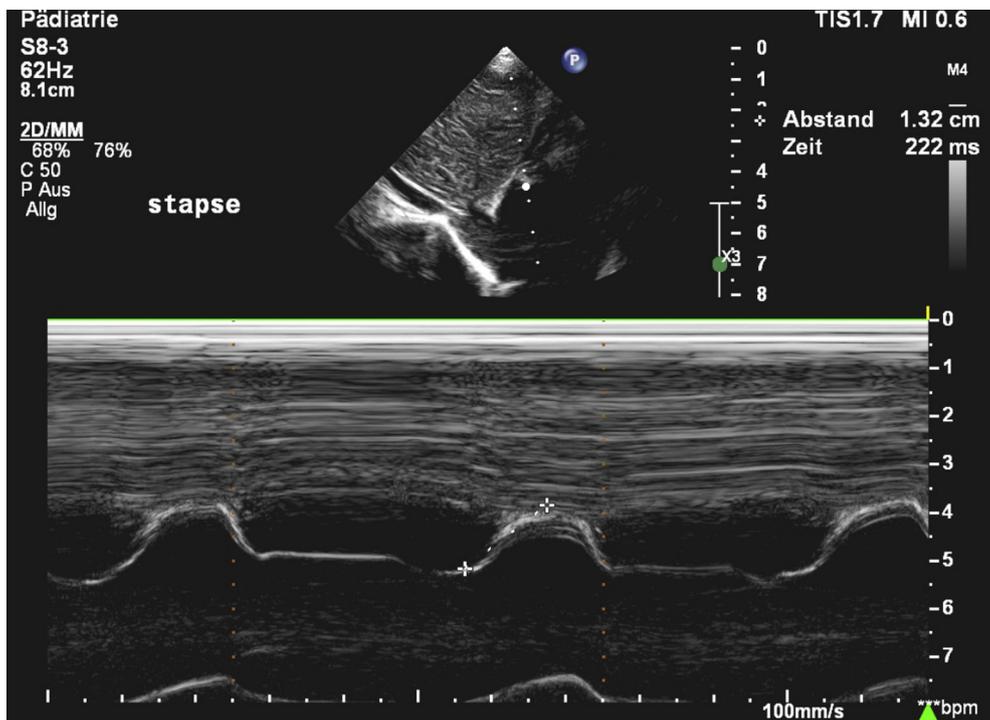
Echocardiographic determination of S-TAPSE using M-Mode from the subcostal view.
